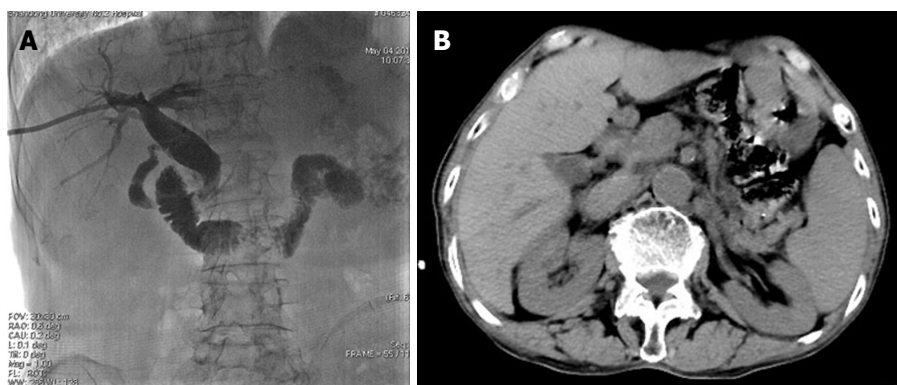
Computed tomography and postoperative cholangiography demonstrating that there was no residual of common bile duct stones or gallstones. A: Intraoperative cholangiography confirmed the absence of all stones and external drainage tube was left; B: Furthermore, 3-5 d after the procedure, cholangiography was performed again with no residual of stones, and the catheter was retrieved.
